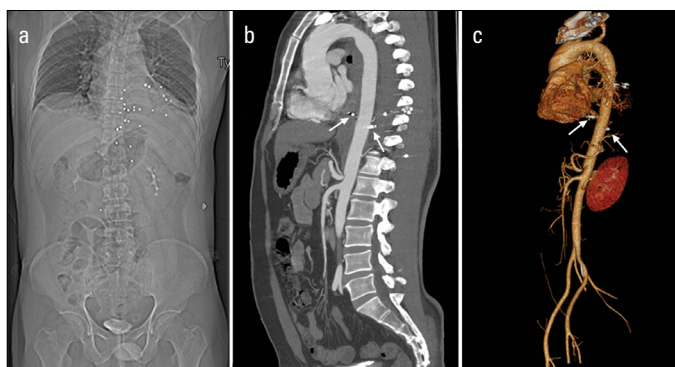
CT image revealing the sites of those pellets, especially those near the descending aorta (arrows)
